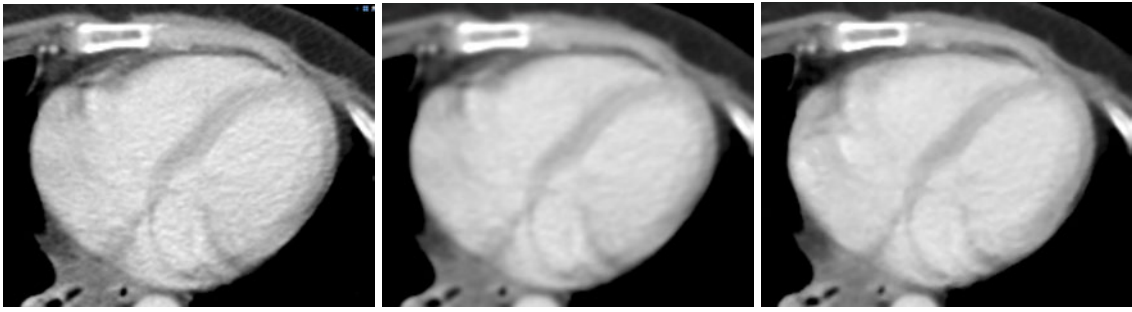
Comparison of Gaussian (middle) with median (right) filtering applied to a CT dataset to reduce noise. The Gaussian kernel was calculated with $\sigma = 1$ and the median kernel had a radius of $r = 1$. Compared to the original image (left), it can be seen that gaussian filtering blurs edges while median filtering can change the content of the image.
